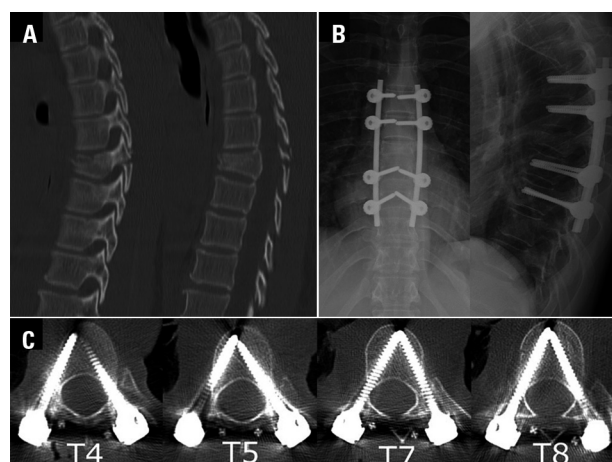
Images of patient # 12: a 16-year-old girl was involved in a motor-vehicle accident and was admitted complaining of back pain (ASIA E). [A] Preoperative CT scan showing a T5-T6 flexion-distraction injury with kyphotic deformity. [B] Postoperative X rays showing good coronal and sagittal alignment and good screw positioning. [C] Postoperative CT scans confirming optimal placement of pedicle screws at all levels instrumented, from T4-T5 and T7-T8.
